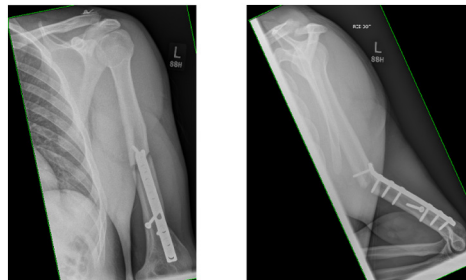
Radiographs: peri-prosthetic fracture of Left humerus shaft, plastic deformation of plate.
